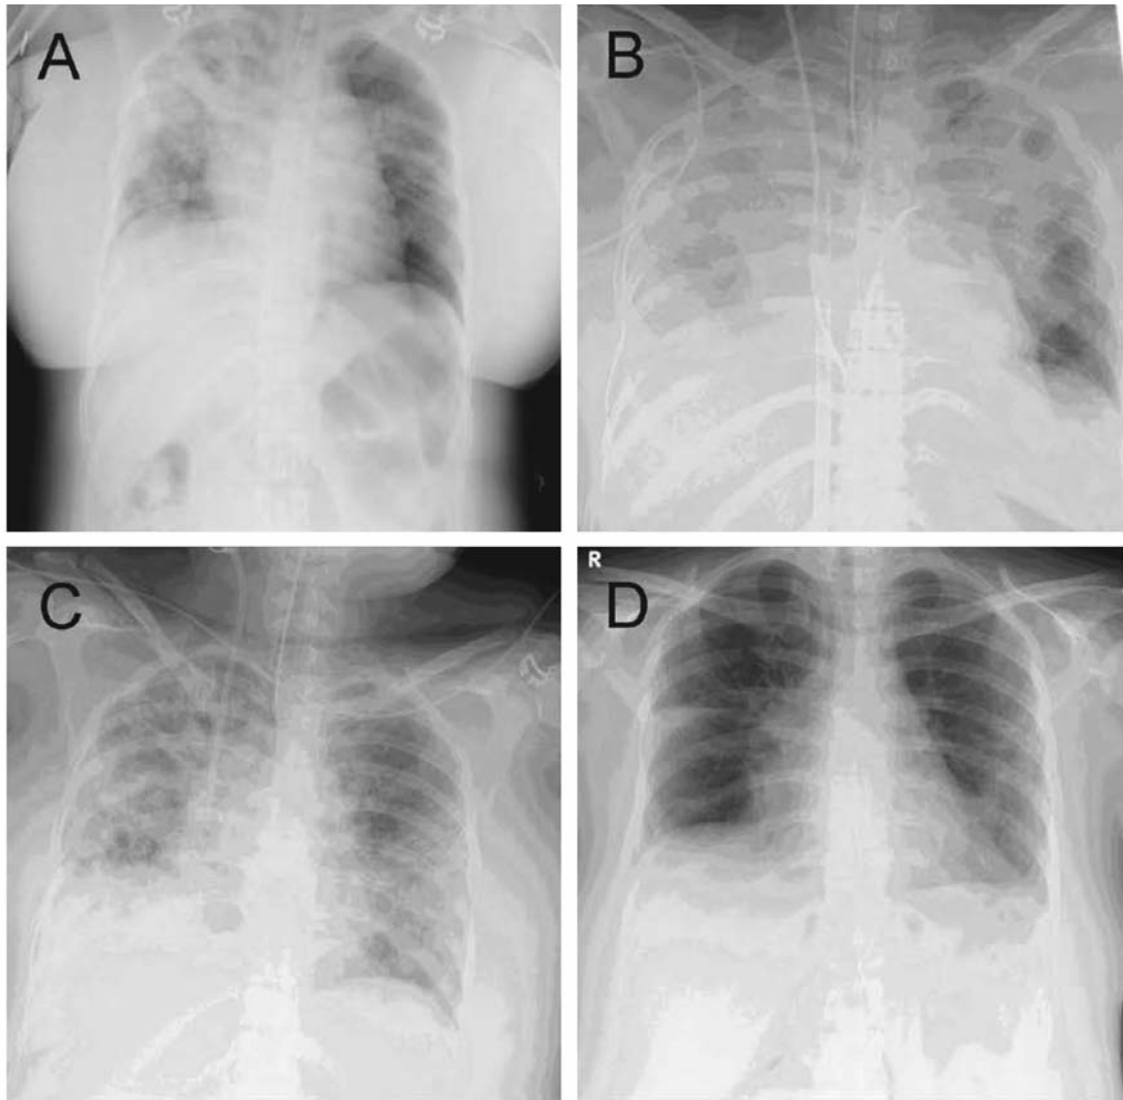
A: Chest radiograph at admission showed bilateral alveolar infiltrates and nodular change mainly on the right side. B: Chest radiograph 11 h after admission, after induction of venoarterial extracorporeal membrane oxygenation. C: Chest radiograph taken after weaning from venovenous extracorporeal membrane oxygenation at day 12. D: Chest radiograph on day 71.
